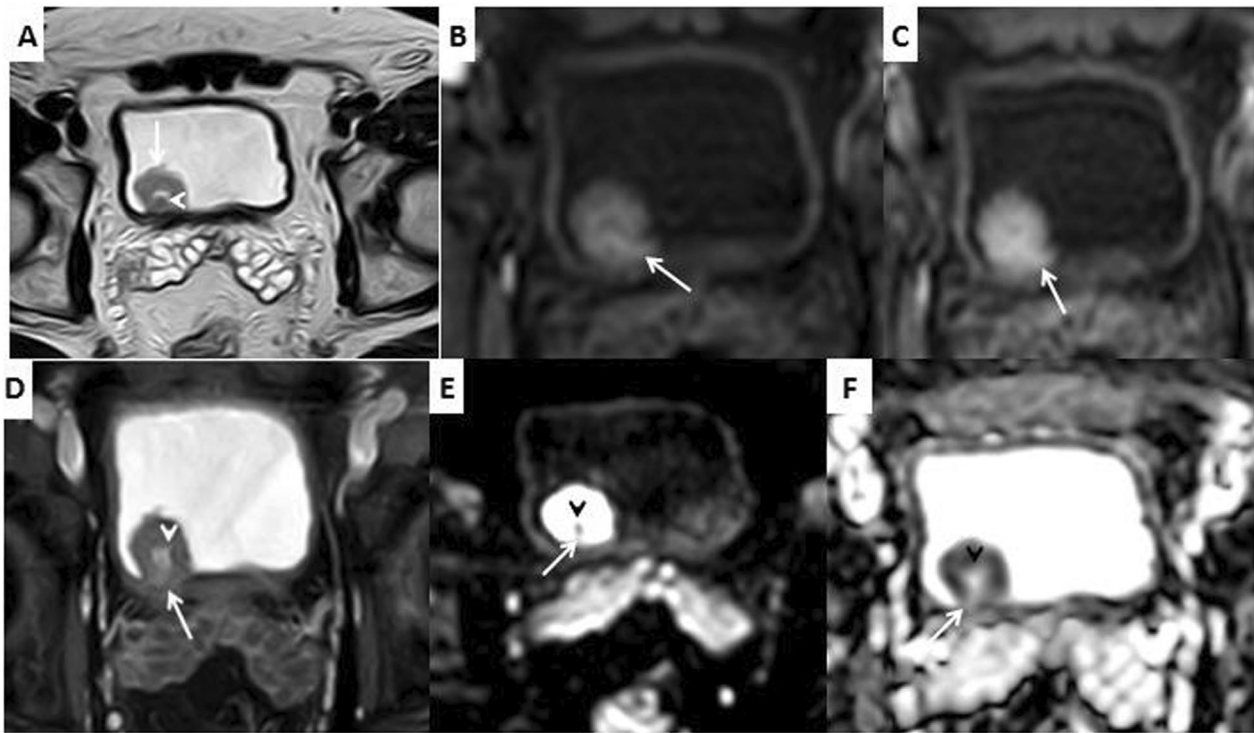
A T2-WI shows a tumor at right posterior urinary bladder wall (arrow) with a stalk (arrowhead). The VI-RADS score for SC category was 2. B–D Axial DCE with early and delayed phases shows early enhancement of the submucosa and uninterrupted muscle layer (arrows) and enhancing stalk (arrow heads). The VI-RADS score for CE category was 2. E, F Axial DWI and ADC map show restricted diffusion of the tumor with ADC value $0.994 \times 10^{-3} \text{ mm}^2/\text{s}$ with a stalk connecting to the posterior bladder wall (arrows). The VI-RADS score for DW category was 2. Final VI-RADS score is 2, denoting that muscle invasion is unlikely to be present. Pathology proved low-grade papillary TCC with no invasion of the muscularis propria
